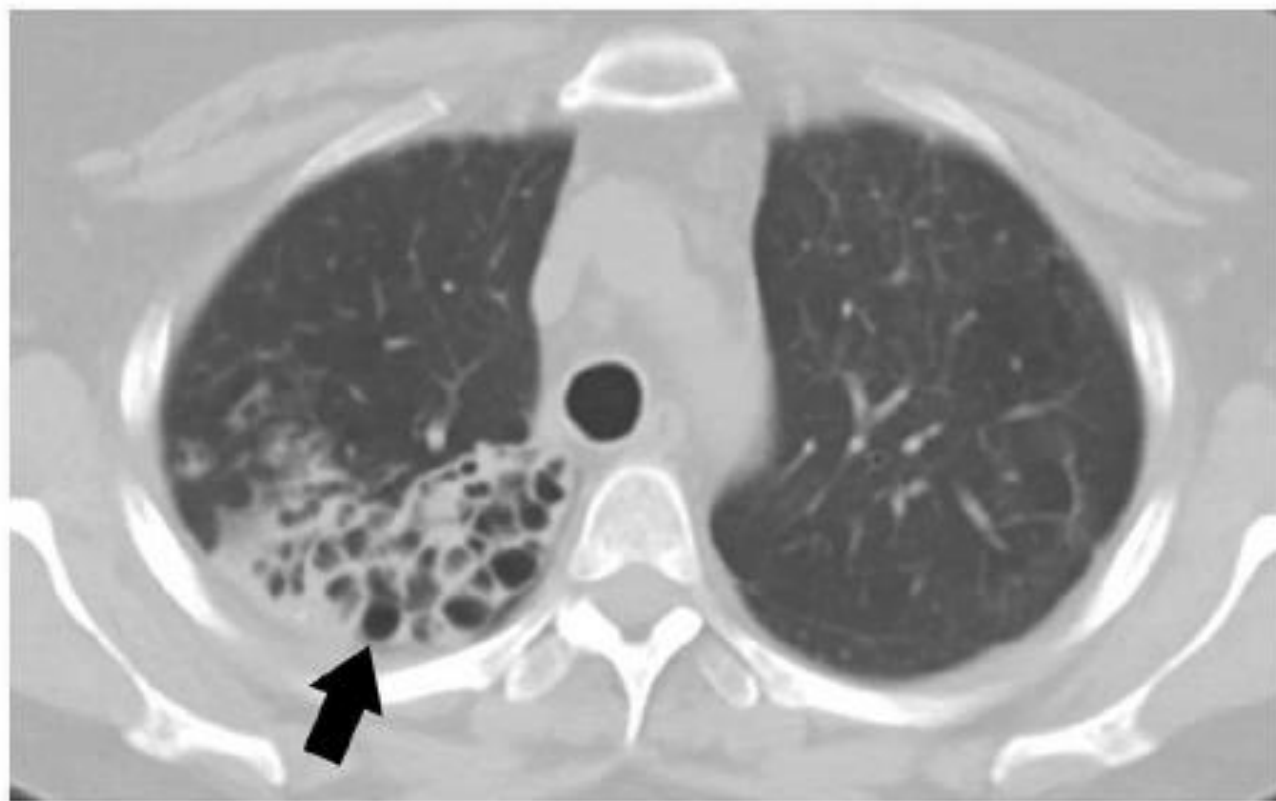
CT scan of a 44-year-old female with primary Sjögren's syndrome demonstrating bronchiectasis on the right lower lobe.
